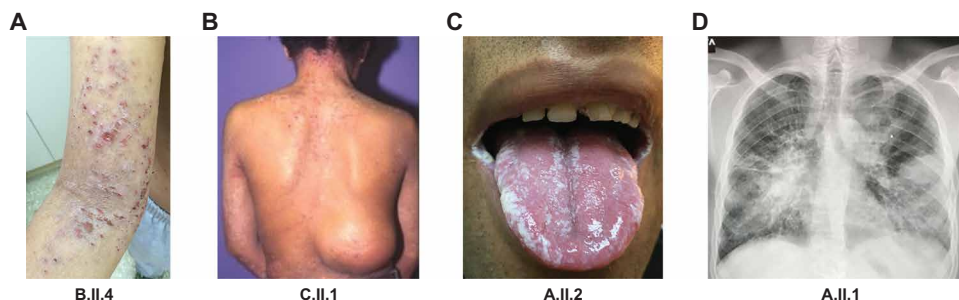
Representative clinical and radiological manifestations in patients with homozygous *ZNF341* nonsense mutations. (A) Severe eczema in patient B.II.4 on the upper arm and cubital. (B) Patient C.II.1 with eczema on the neck and a cold skin abscess in the lumbar region missing the typical inflammatory signs of rubor, calor, and dolor. (C) Oral thrush due to *Candida* in patient A.II.2. (D) Chest radiograph of patient A.II.1 showing bilateral pneumonia with positive air bronchogram, bronchiectasis, and pneumatoceles.
